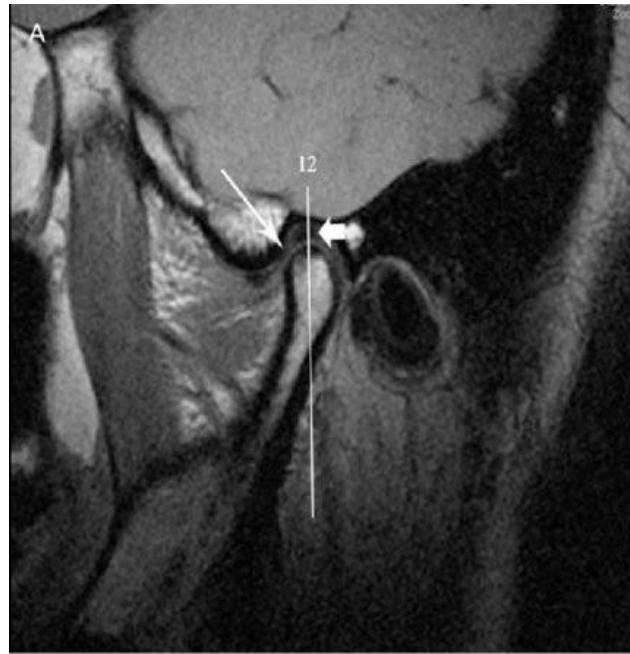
MRI appearance of normal TMJ disc morphology
